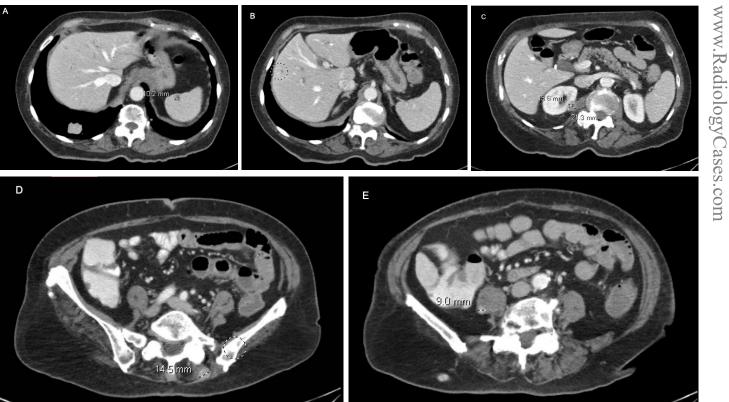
February 2018. CT chest abdomen pelvis with contrast. Axial view. Progression with new splenic and liver lesions, kidney, soft tissue, and pancreatic lesions suspicious for metastases.
